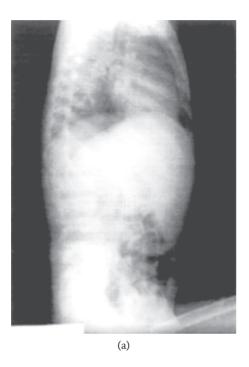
Initial lateral radiographs.
